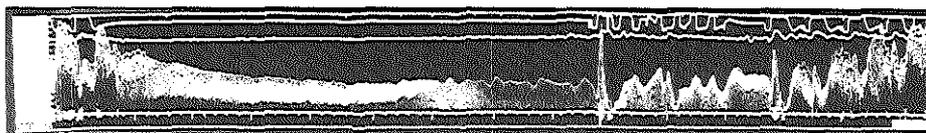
Prolonged diastolic pause induced by the intracoronary injection of 3 mg of adenosine during maximal hyperemia induced by papaverine. A progressive decrease of flow velocity and aortic pressure is observed during the 6 seconds of cardiac arrest. In the first beats induced by ventricular pacing, note the presence of a large systolic flow component, indicating refilling of the capacitance of the epicardial coronary artery. The dotted tracing at the top of the Doppler envelope indicates the instantaneous peak velocity (automatically detected on-line and used for the analysis of the pressure-velocity relation).
